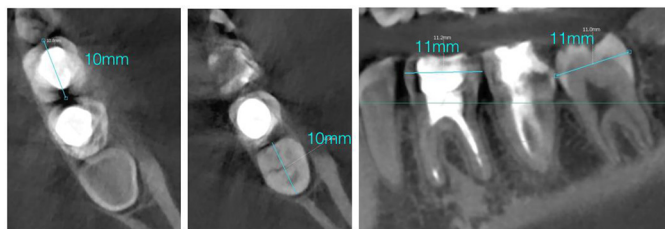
Cone beam computed tomography sections and three-dimensional analysis of teeth 36 and 38.
